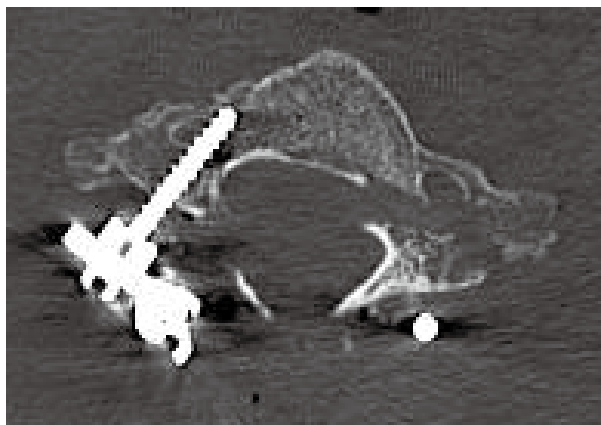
Postoperative computed tomography scan showing lateral minor breach of the pedicle in a patient with a lamina fracture.
